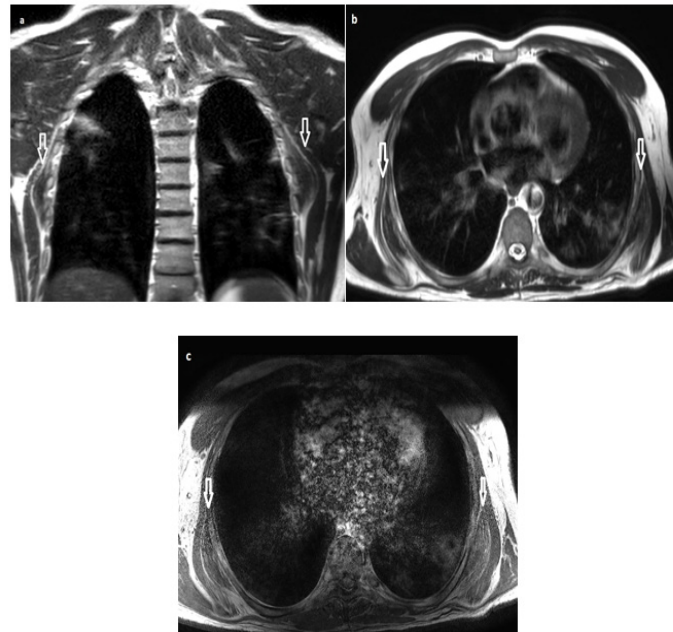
MRI of the dorsal region in T2-weighted sequences in coronal (a) and axial (b) sections, and in T1-weighted sequences in axial (c) section showing a striated bilateral sub-scapular oval mass, alternating bands of fibro elastic tissue in iso signal T1 and T2 and bands of fatty tissue in hyper signal T1 and T2 (arrow) realizing the aspect in thousand leaves.
